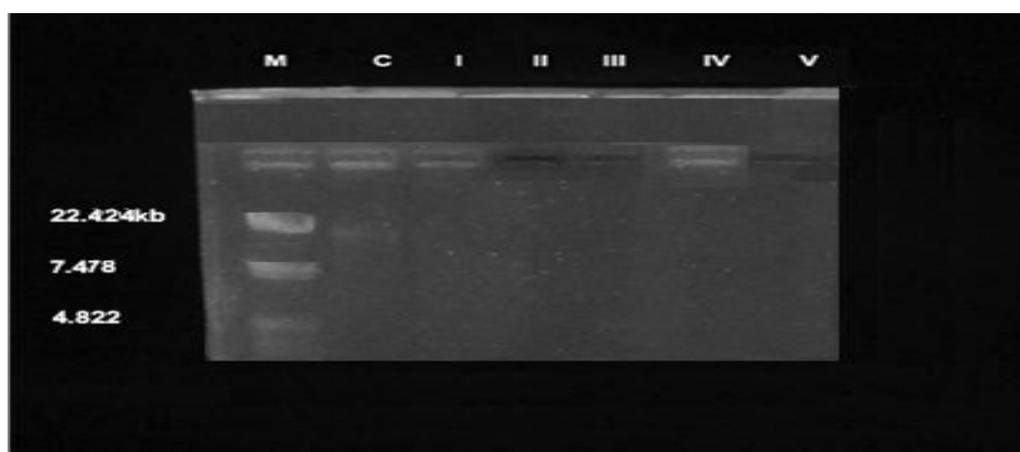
DNA Cleavage study Calf-thymus (CT) -DNA with Cu (II), Ni (II), Co (II), Mn (II) and Zn (II) Complexes. M: Standard Molecular weight Marker; Calf-thymus – Control DNA; Lane 1: Cu (II) (I); Lane 2: Ni (II) (II); Lane 3: Co (II) (III); Lane 4: Mn (II) (IV); Lane 5: Zn (II) (V)
